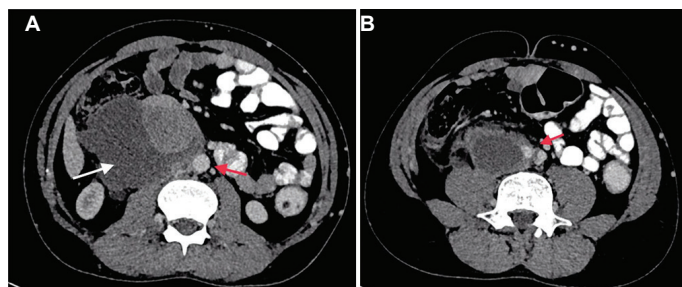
(A) Computed tomography (CT) of the abdomen showing the nodal mass (white arrow) in the paracaval area with complete invasion of inferior vena cava (IVC) and right ureter and abutting the aortic wall (aorta indicated with red arrow). (B) CT abdomen showing complete encasement of the right common iliac artery (red arrow).
